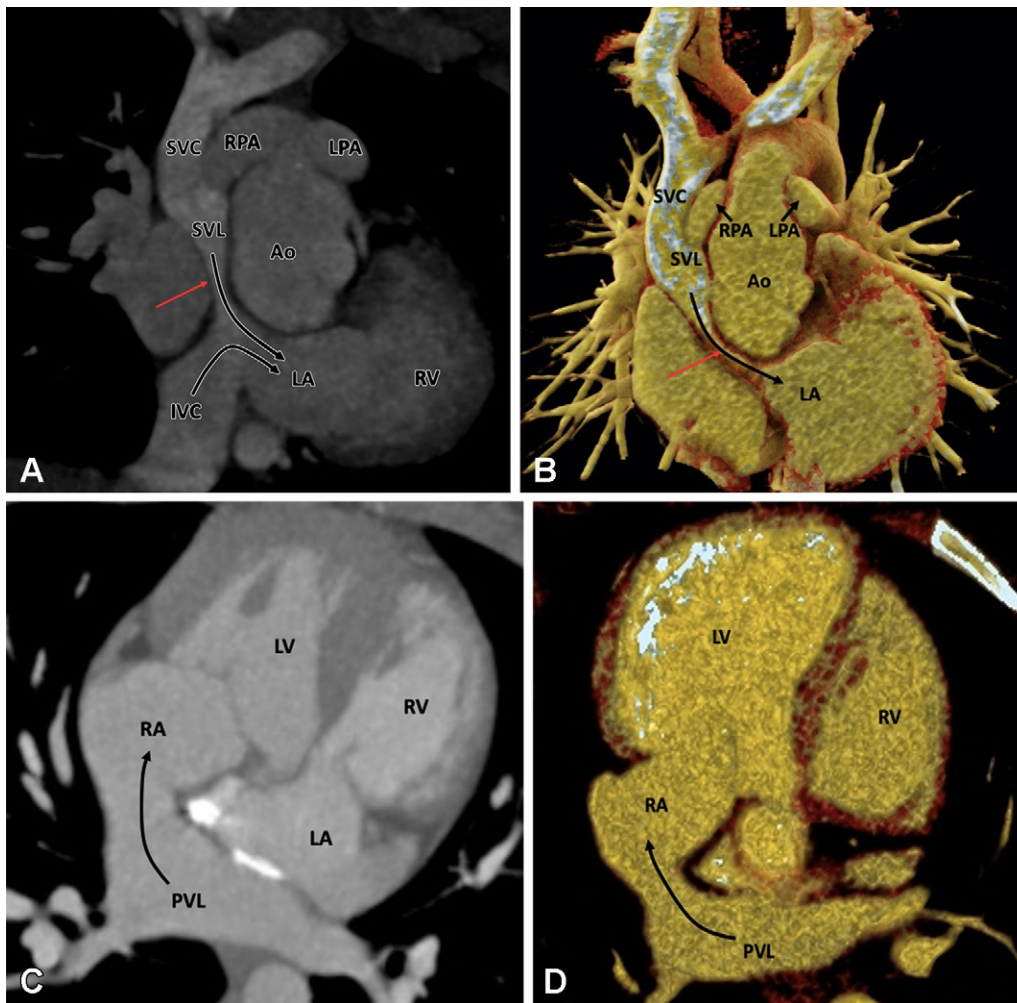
Postoperative appearance of levotransposition of the great arteries after double-switch operation (Senning procedure and arterial switch) in an 8-year-old boy. (A) Coronal oblique maximum intensity projection (MIP) CT image and (B) coronal oblique cut volume-rendered image show the systemic venous limb of the baffle emptying systemic venous blood into the left atrium and morphologic right ventricle (long curved black arrows). There is evidence of severe stenosis in the systemic venous limb (red arrow). Also, note the right and left pulmonary arteries (short straight black arrows in B) lying on either side of the aorta as the normal postoperative appearance of LeCompte maneuver. (C) Axial MIP CT image and (D) axial cut volume-rendered images show the pulmonary venous limb of the baffle emptying pulmonary venous blood into the right atrium and morphologic left ventricle (long curved black arrow). Ao = aorta, IVC = inferior vena cava, LA = left atrium, LPA = left pulmonary artery, LV = left ventricle, PVL = pulmonary venous limb, RPA = right pulmonary artery, RA = right atrium, RV = right ventricle, SVC = superior vena cava, SVL = systemic venous limb.
